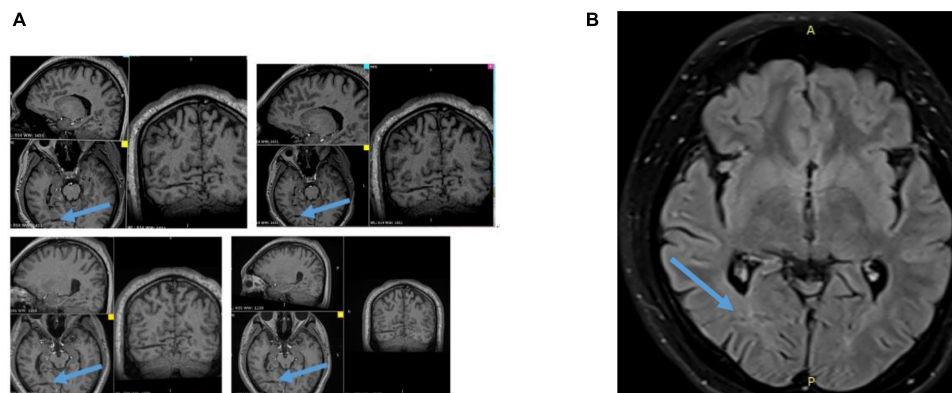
(A) Follow-up for 58 months, 3D MRI showing a trace of RFTC at the post-GMNH every year from 2016 to 2019. (B) T2 Flair of MRI showing a trace of RFTC at the POST-GMNH and overlying cortex. Blue colored arrow showing a trace of RFTC.
